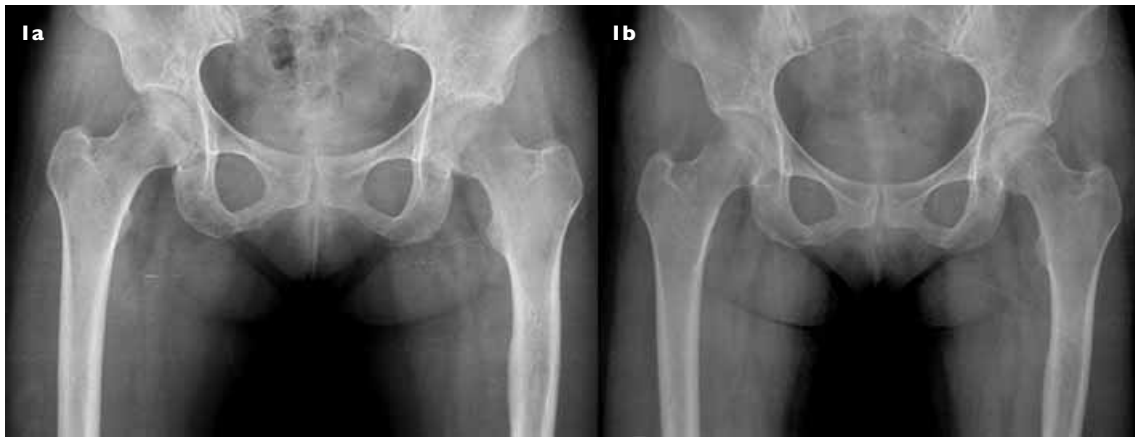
Case 1. (a) Anteroposterior pelvic radiograph shows osteopenia with loss of a trabecular pattern in the left femoral head. (b) Radiograph taken nine months later shows complete recovery with equal density of both femoral heads.
